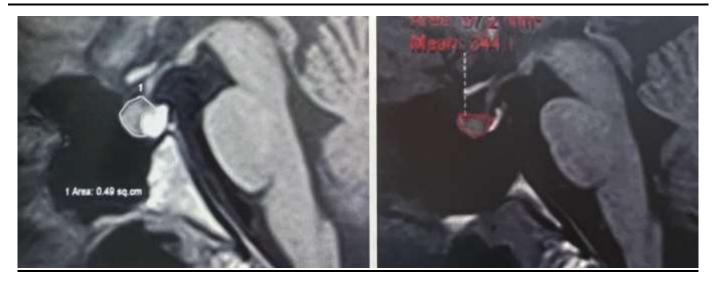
A 19 year old female with history of depression, underwent MRI of the Brain.
